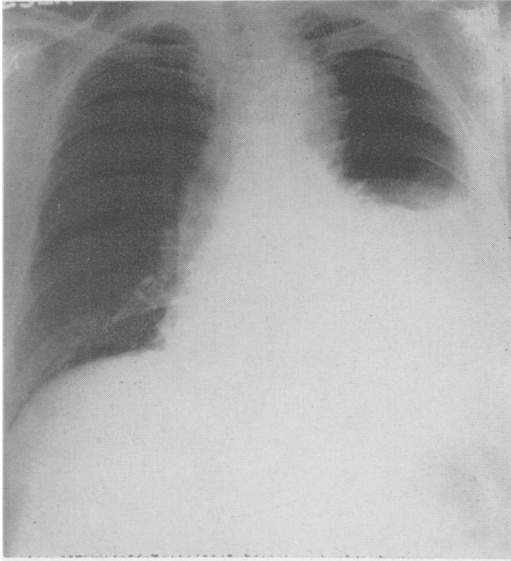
Roentgenogram of chest in Case 6, showing presence of pleural fluid in left hemithorax and enlargement of the aortic shadow.
